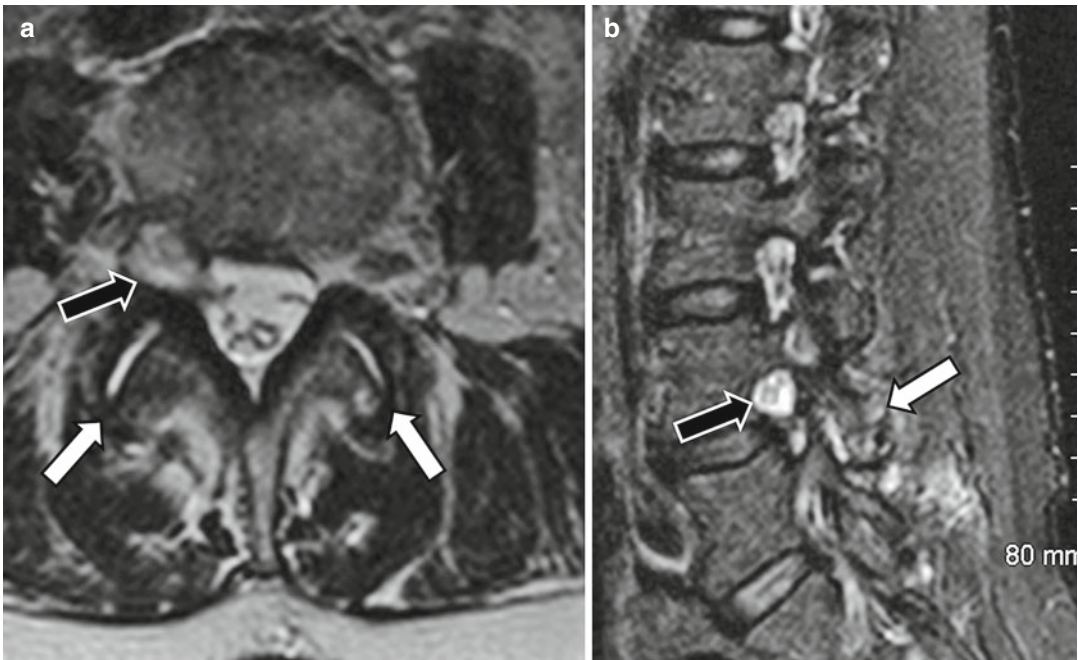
A 55-year-old woman presenting with acute right-sided radicular. Axial T2-weighted (a) and sagittal short-tau inversion-recovery (STIR, b) images demonstrate large high T2 signal lesion filling the right L4–5
